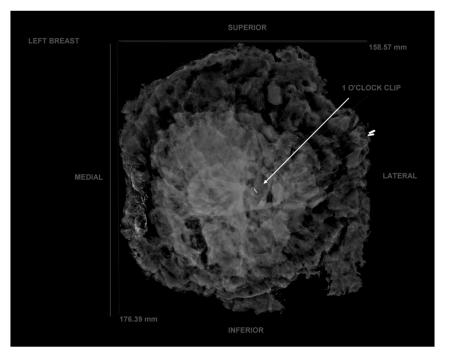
Example of radiographic image taken before gross dissection using the Faxitron PathVision system and annotated with direction labels, dimensions, and an arrow denoting a microclip.
